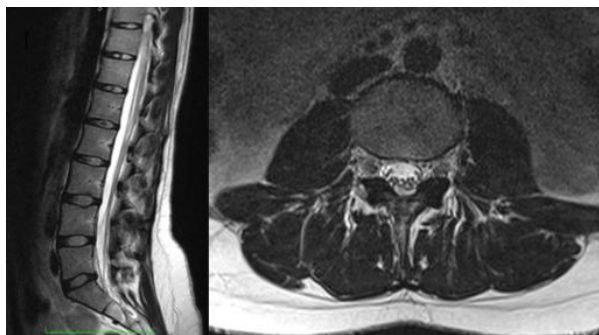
Lumbar MR images of the patient was evaluated by reason of LBP
